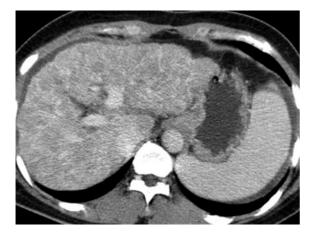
Regenerative nodule: CT appearance. Delayed phase CT scan also shows multiple nodules which are separated by hyperenhancing fibrous tissues in the liver. Note nodularity of liver contour, splenomegaly and small amount of ascites
